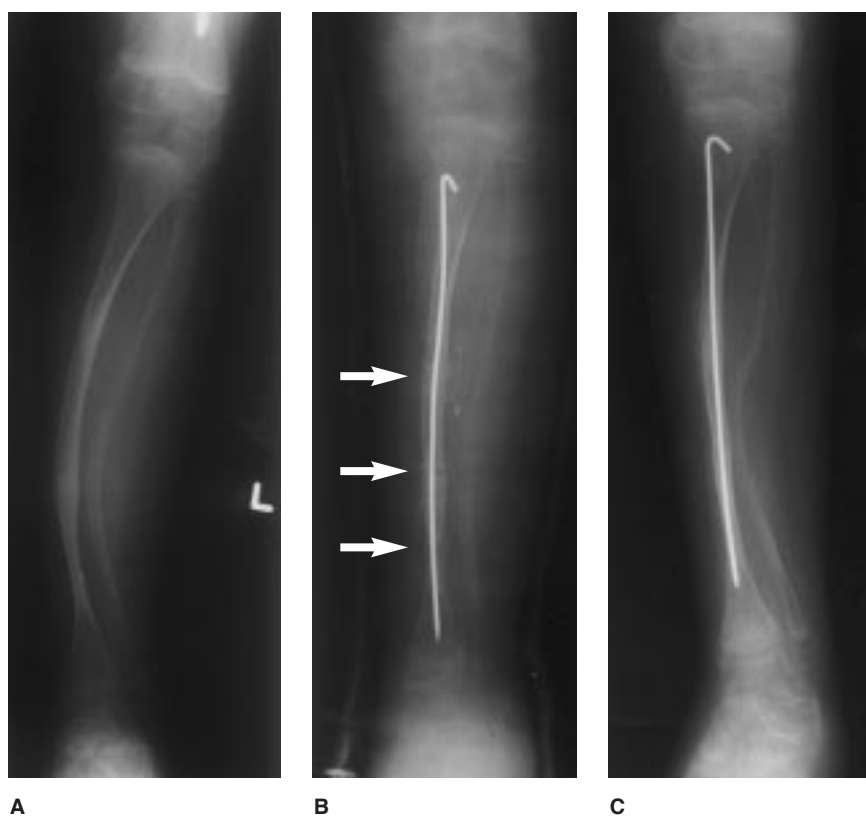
Leg deformity in a patient with type III OI. A, Preoperative AP radiograph obtained at age 6 years demonstrates deformity. B, Postoperative film with leg in cast shows multiple osteotomies (arrows) with intramedullary fixation. C, Film obtained after healing of osteotomies.
